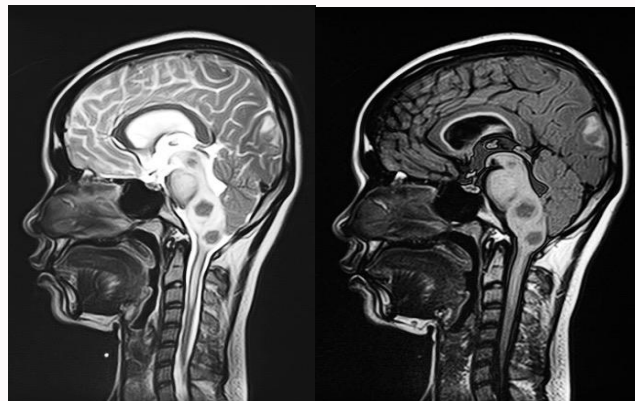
Multiple hypointense lesions at brainstem (T2 weighted image & T2 FLAIR) – pre treatment.
